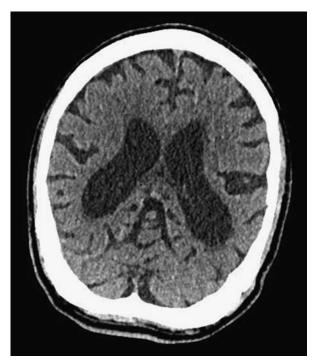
Computed tomography of the brain without intravenous contrast obtained on admission demonstrated moderate diffuse parenchymal atrophy with enlarged ventricles and sulci, which were slightly increased from 1 year prior, but with no acute intracranial abnormality.
